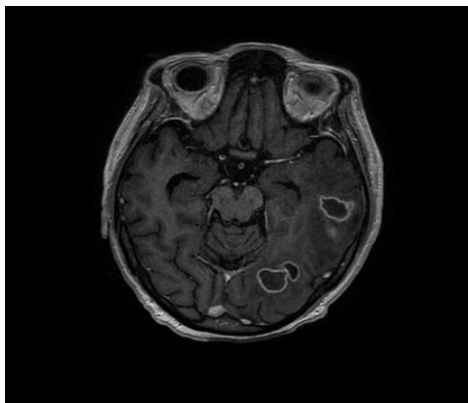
Axial brain MRI with gadolinium showing multiple ring-enhancing cerebral lesions with perifocal oedema and mass effect in the left hemisphere.
